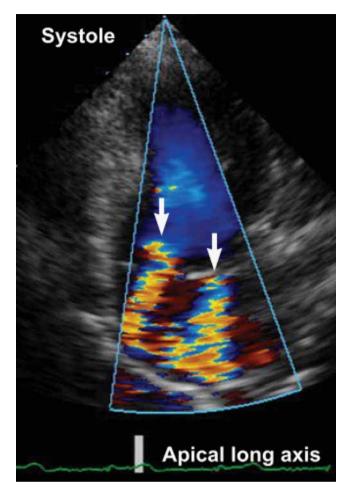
Narrow sector scan (color flow Doppler) showing two separate mitral regurgitant (MR) jets viewed from the apical long axis view. This was confirmed when viewed from multiple windows. When assessing multiple MR jets, each jet should be analyzed and reported separately. Vena contract widths (VCW) measurements are invalid when multiple MR jets are present.
